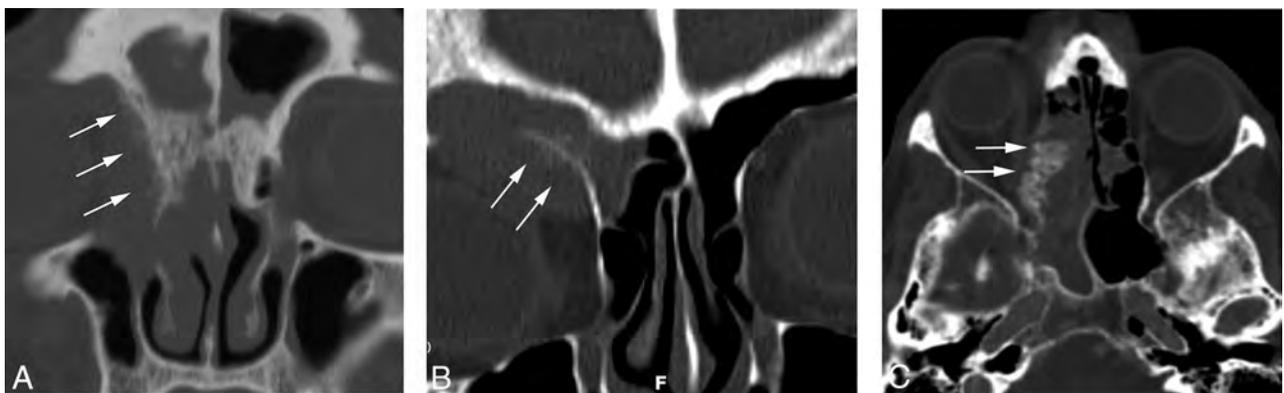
Calcification. A, Patient 9. Coronal CT bone image demonstrates spiculated, “hair on end” calcification along right medial orbital wall, with permeative lytic change in the adjacent bone (*arrows*). B, Patient 13. There is a similar pattern of “hair on end” calcification involving the floor of the right frontal sinus on this coronal CT image (*arrows*). In both patients, the involved bone is demineralized but not destroyed. C, Patient 11. There is a more solid, floccular pattern of calcification along the right medial orbital wall on this axial CT image (*arrows*).
